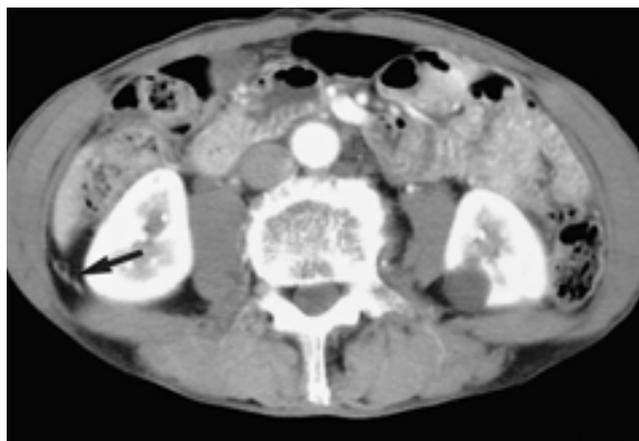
A 69-year-old gastric cancer patient without peritoneal carcinomatosis. CT scan shows thin enhancing irregular line (arrow), mimicking thickened peritoneum due to tumor seeding. However, there were no evidence of peritoneal thickening, adhesion, and ascites at surgery.
